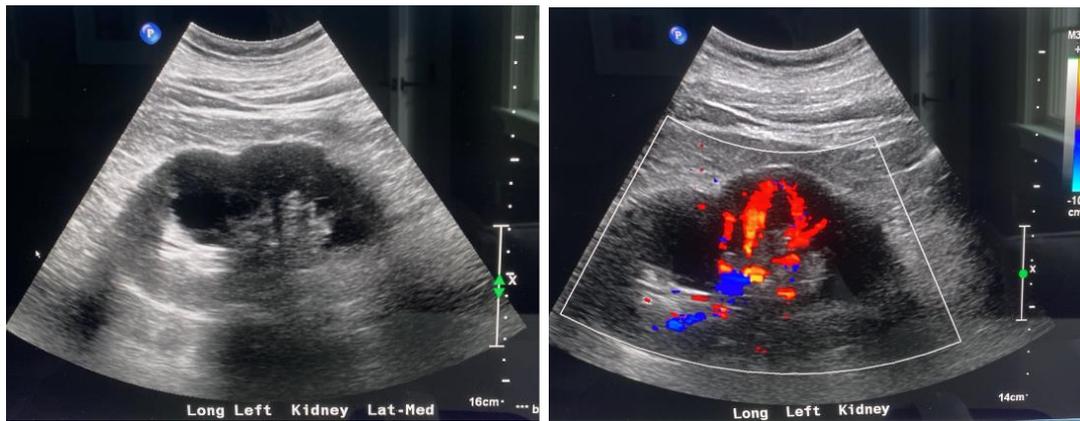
Left Kidney ultrasound.
